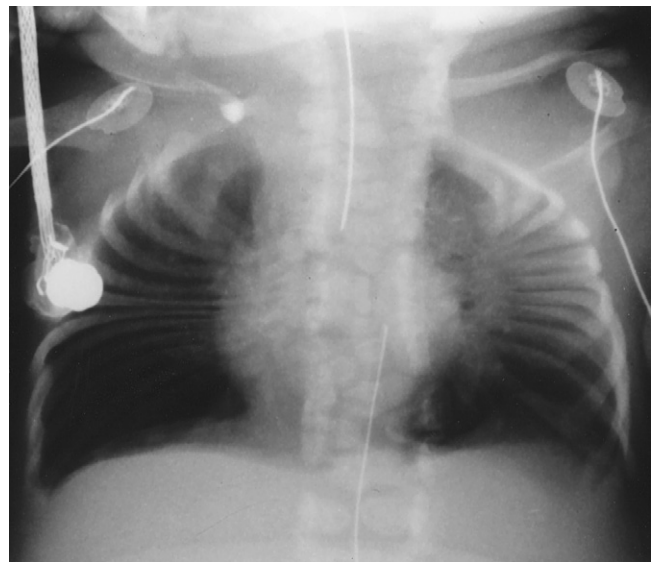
Chest radiograph of an infant with spondylothoracic dysplasia. Severe abnormality of the spine is apparent, with multiple alternating hemivertebrae and the crablike ribs. (From Shamberger RC: Chest wall deformities. In Shields TW [ed]: General Thoracic Surgery, ed 5. Philadelphia, Lippincott Williams & Wilkins, 2000.)
